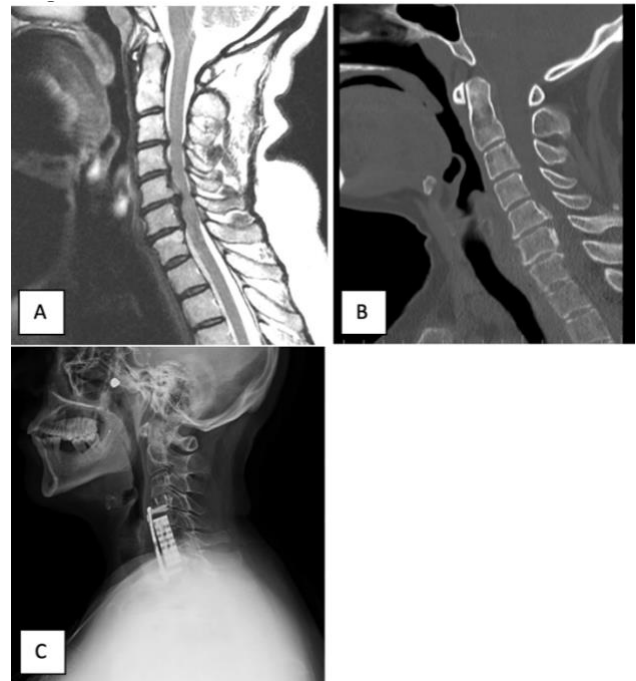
Imaging findings in a patient with two-level cervical spondylotic myelopathy. A. Preoperative sagittal T2-weighted images show severe stenosis at the C5–C6 level. B. Computed tomography scan of the cervical vertebra in the sagittal plane without contrast enhancement in the preoperative phase shows a calcified herniated disc in the bone window. C. Postoperative lateral neutral cervical radiograph showing C5 and C6 corpectomy cage, anterior cervical plate, and peek cage at the C3–C4 space.
